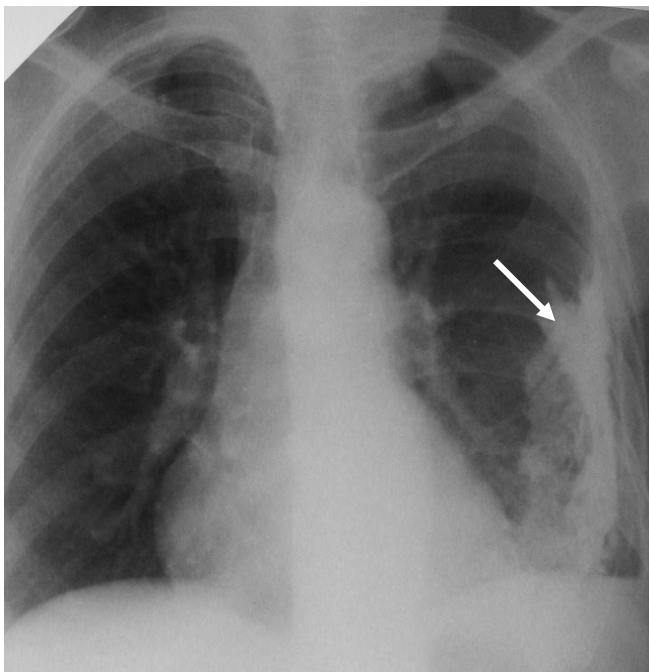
The frontal chest radiograph. There is an intensive limited shadow with accurate rough contours in the left pulmonary field. The shadow is more intensive in the lateral department (arrow). Calcification pleurae on the left
